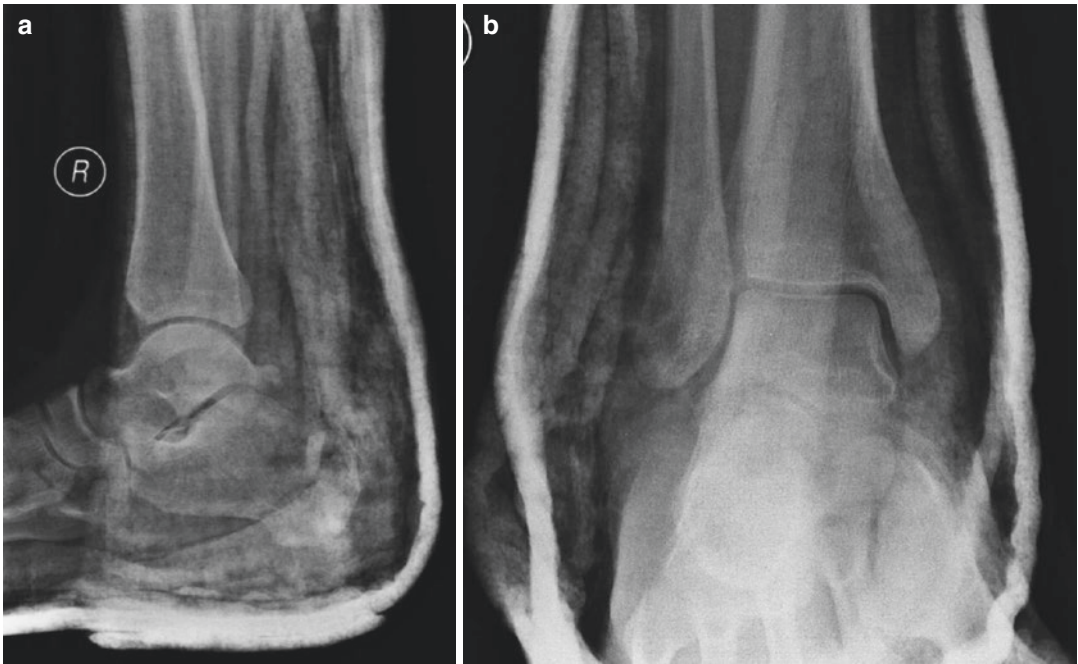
(a, b) Post reduction radiographs for Case 2. “Post-reduction radiographs show concentric reduction of the subtalar joint”
